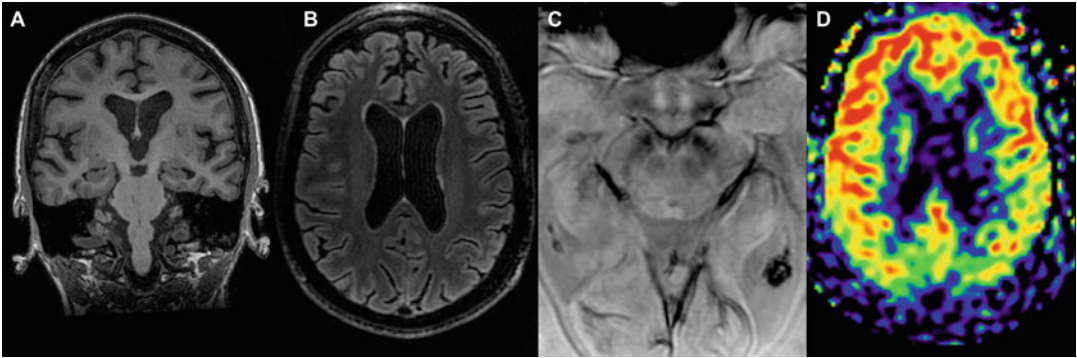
Normal report of a 72-year-old woman. Para-coronal (along the axis of the temporal lobe) reformatted T1w (a), axial reformatted 3D T2w FLAIR (b), zoom of axial susceptibility imaging (c), and axial ASL (d)
